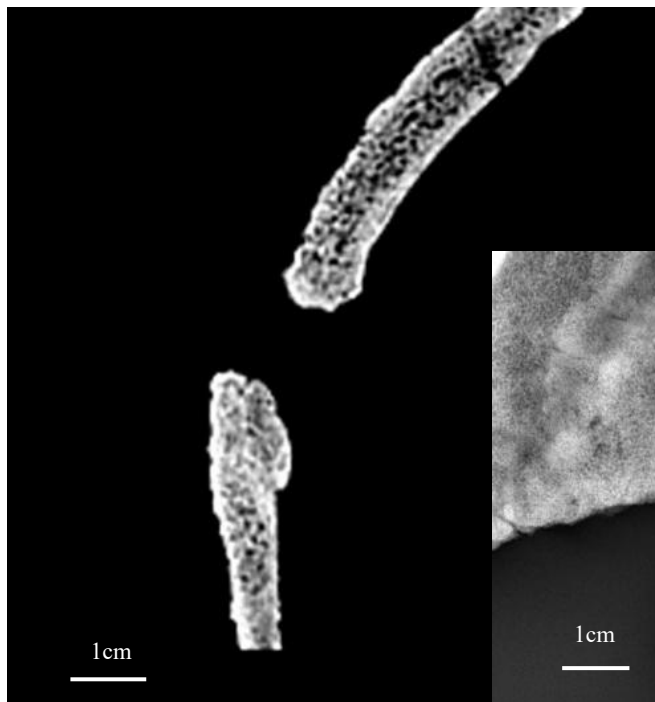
Sagittal CT slice of the skull from SEP 33 (position: L = 562; W = 1873), showing a funnel-shaped lesion and local thickening of the internal table. Collège Claude Monnet, Magny-en-Vexin, excavation of 1998.
